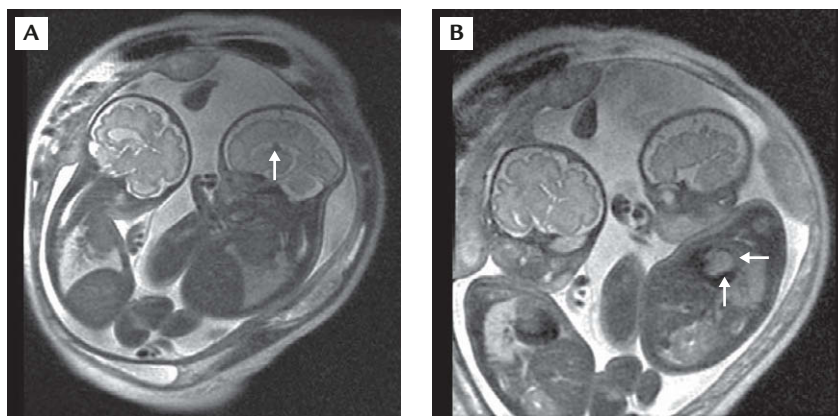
Ultrafast magnetic resonance imaging showing (A) small subependymal tubers and (B) intracardiac tumors in the co-twin affected with tuberous sclerosis complex.
